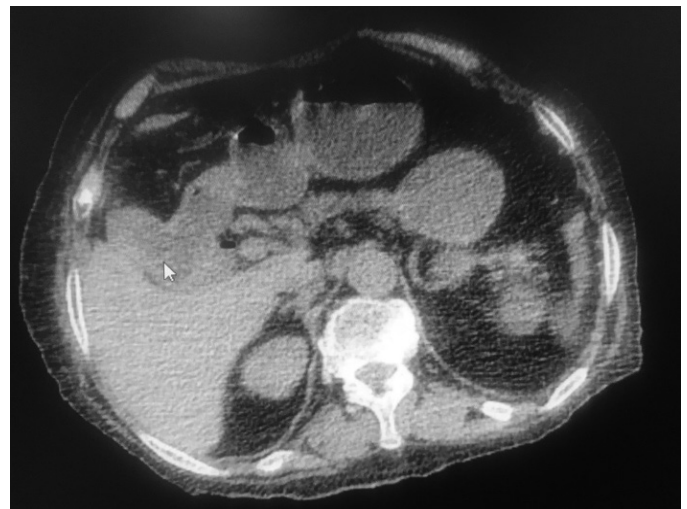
CT scan showed air in the gallbladder and intrahepatic bile ducts
